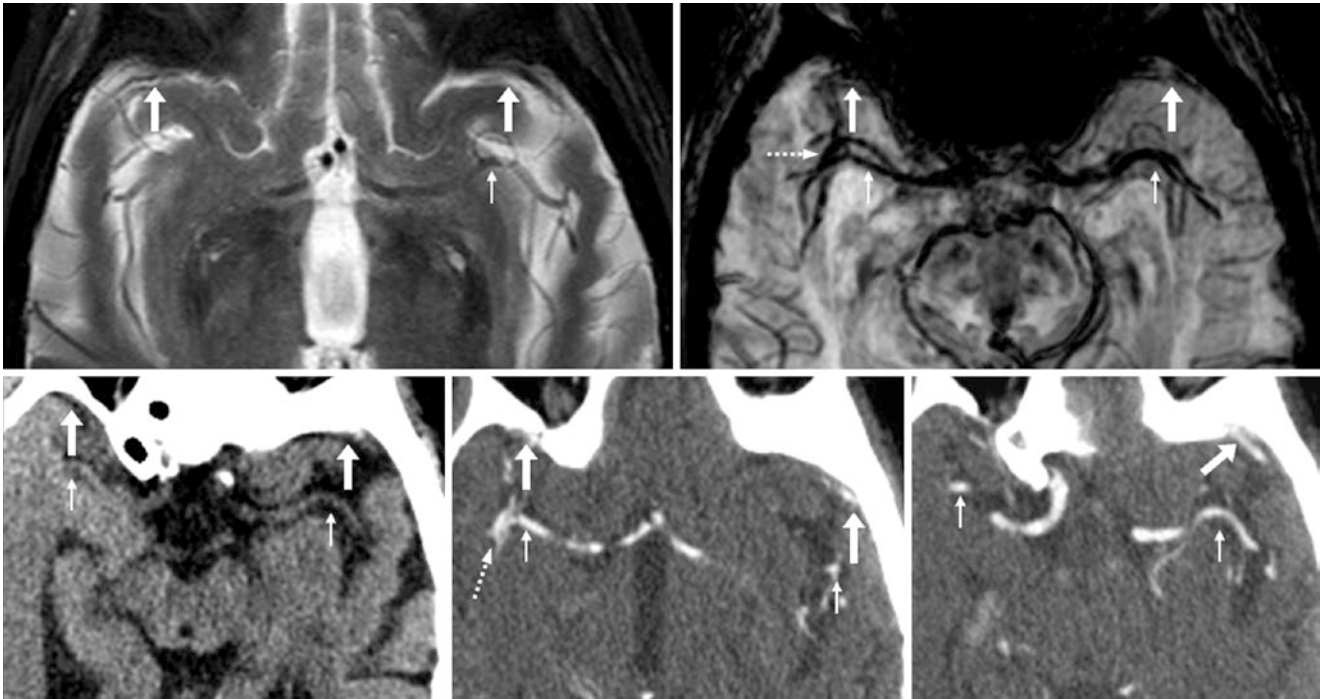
84-year-old with bilateral flow voids from SPSVs (*large arrows*) on T2WI (*top left*) and 10 mm thickness SWI (*top right*), with the MCAs (*thin arrows*) located posteriorly. On nonenhanced CT (*bottom left*), the left SPS is hyperdense from beam hardening artifact
